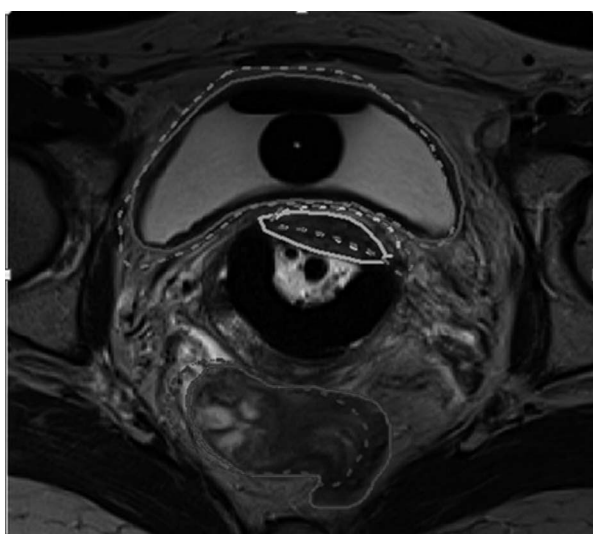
Figure showing the overlapped contours for the HRCTV and the OAR. While the width of the CT contours of the HRCTV is larger, the contours of the OAR seem to nicely overlap.
